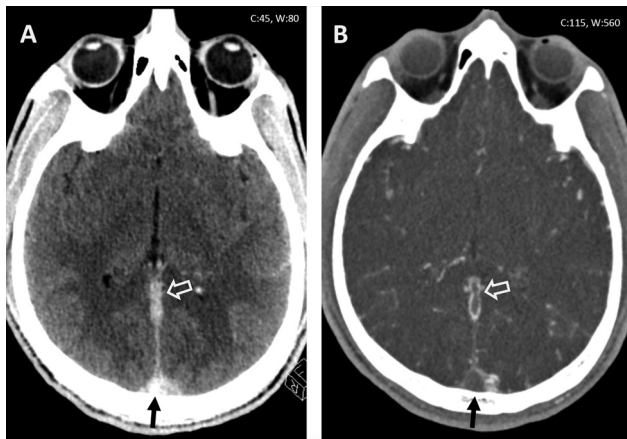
Noncontrast computed tomography (NCCT) in (A) and computed tomography venography (CTV) in (B) show evidence of thrombosis in superior sagittal sinus (black arrow) and vein of Galen (open white arrow). High attenuation is evident in the thrombus on the NCCT. The empty delta sign with a triangular filling defect in superior sagittal sinus is clearly demonstrated on the CTV.
